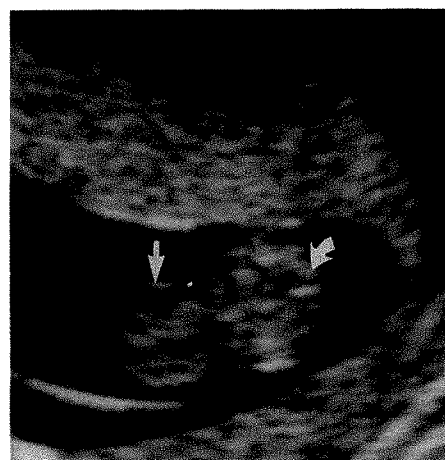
Transverse sonogram through fetal abdomen at 10.2 weeks gestational age. Herniated mass of omphalocele (straight arrow) is only slightly smaller than fetal abdomen (curved arrow). Transverse diameters of omphalocele at this level are 8 and 9 mm, and those of abdomen are 9 and 10 mm.
